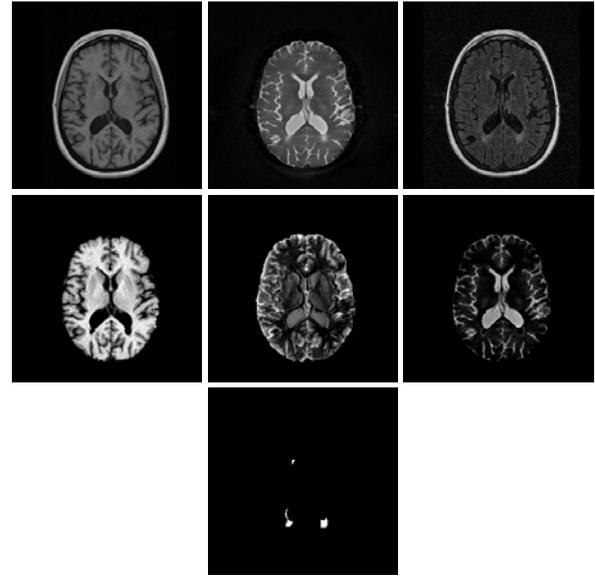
One slice of the T_1 -, T_2 -weighted, FLAIR images (top), the PV mixture segmentation of WM, GM, and CSF (middle), and the detected lesions (bottom).
